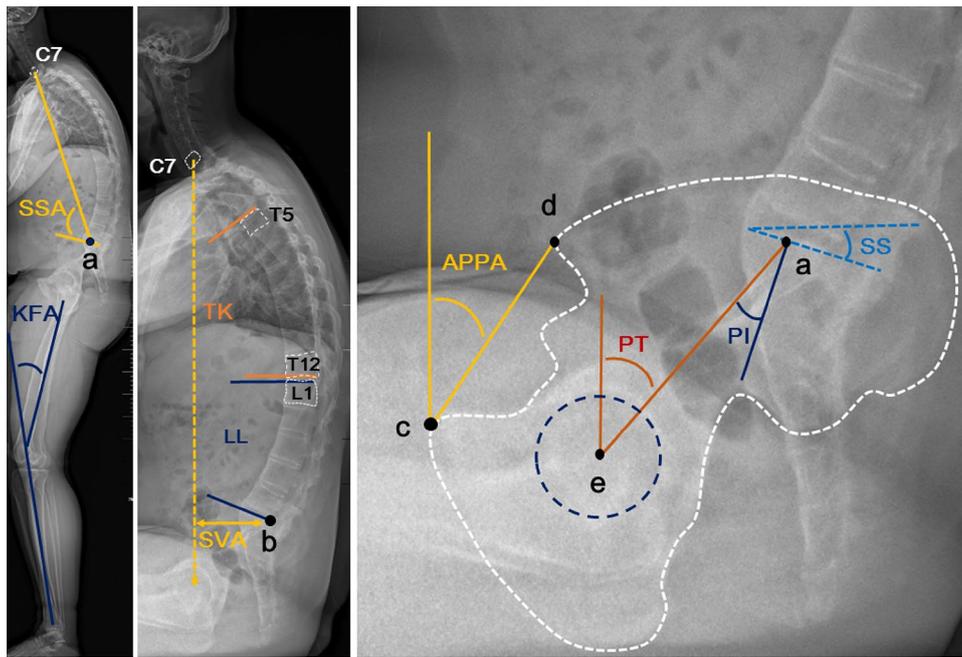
A radiograph showing the measurements of radiographic parameters on EOS lateral images. Spinosacral angle (SSA) indicates the angle between the sacral plate and a line from C7 to the midpoint of the sacral plate (point a). Knee flexion angle (KFA) was measured as the angle between the mechanical axes of the femur and tibia. Sagittal vertical axis (SVA) was measured as the horizontal distance between the C7 plumb line and the posterior superior corner of S1 (point b). Thoracic kyphosis (TK) was the angle between the superior end plate of T5 and the inferior end plate of T12. Lumbar lordosis
